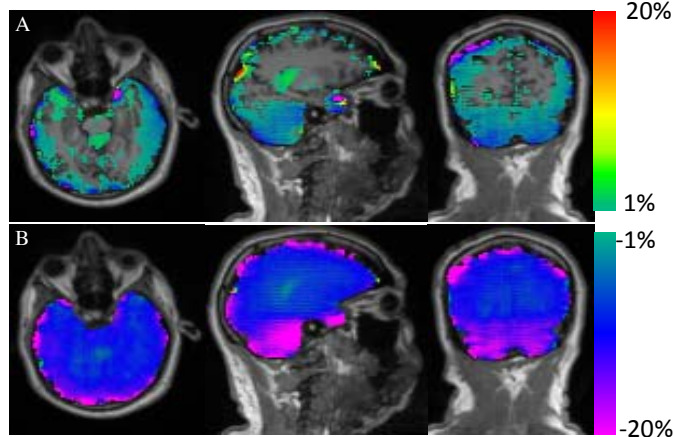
Representative percent-error maps of PET reconstructions using the proposed method (A) and vendor method (B) overlaid on T1-MR images are shown here. Errors less than $\pm 1\%$ and larger than $\pm 20\%$ were suppressed.
